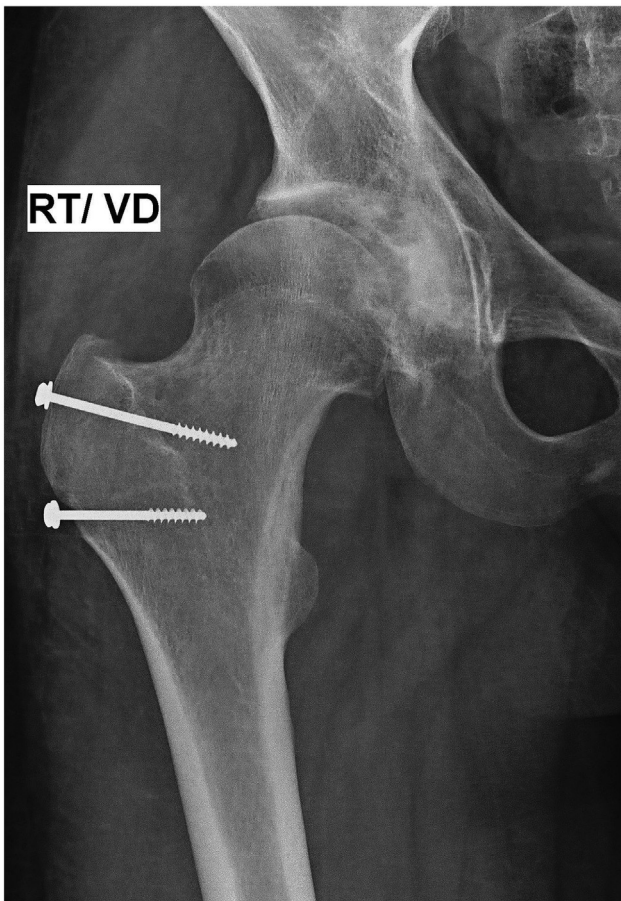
Follow up radiograph of the patient with fixation of trochanteric fragment and complete removal of acetabular osteochondroma.
